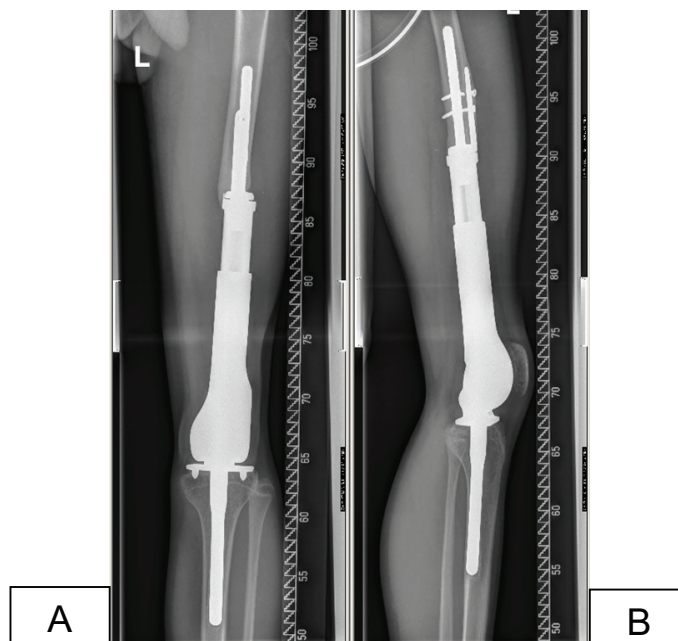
A & B: X-rays a/p and lateral: male patient from Department of Orthopedic Surgery Graz, A: 14 years old; B: 4 years following implantation of a minimally invasive HMRS prosthesis
